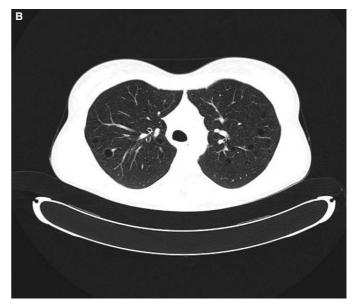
Figure (A and B). Computed tomography showing emphysematous bullae in both lungs and marked centrilobular and panlobular emphysematous changes with multiple pseudocystic formations ranging in diameter from a few millimeters to 2 cm in both lungs.
